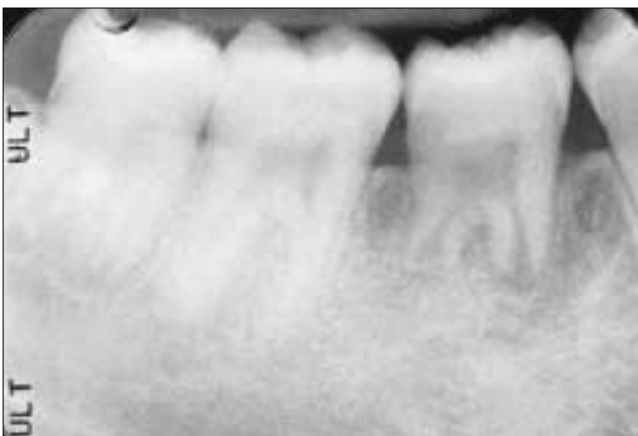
Six-month post-operative radiograph indicates patient has regained the supporting alveolar bone in the region of the tooth transplant and shows continued root development with the establishment of a periodontal ligament space.
